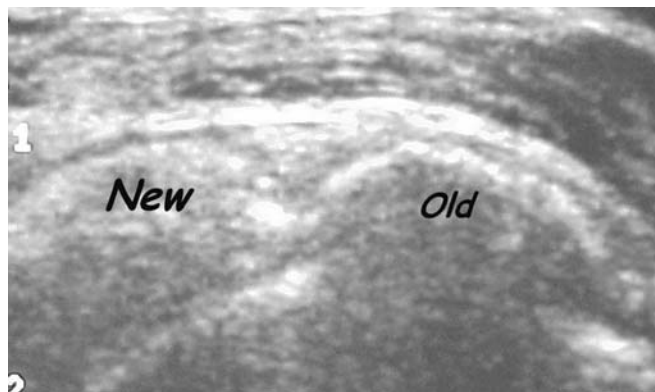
Transverse ultrasound of the supraspinatus tendon showing the different morphology of calcific tendinitis. The old calcium has a strong superficial spectral echo and deep shadow and is unlikely to drain via needle aspiration.
